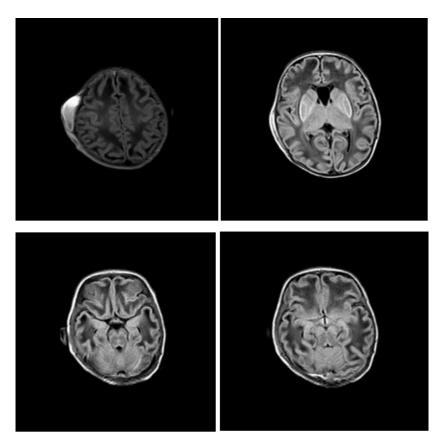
Subtle T2 FLAIR hyperintensity is noted in bilateral cerebral hemispheres, cerebellum white matter, brain stem, thalami and basal ganglia. Hyperintense lesion seen in right fronto-parietal region of scalp with blooming on GRE - cephalhematoma
